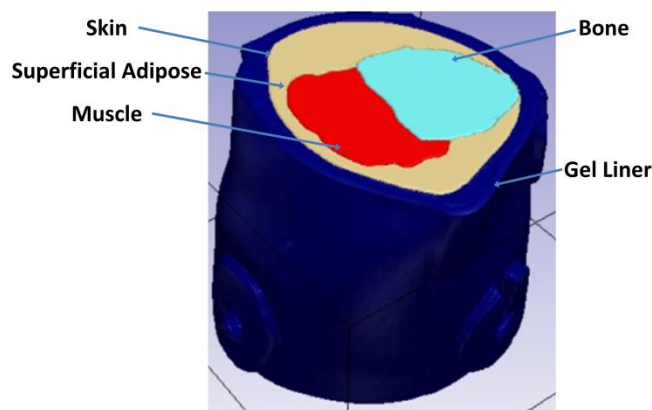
Segmented participant #1A baseline MRI stack
